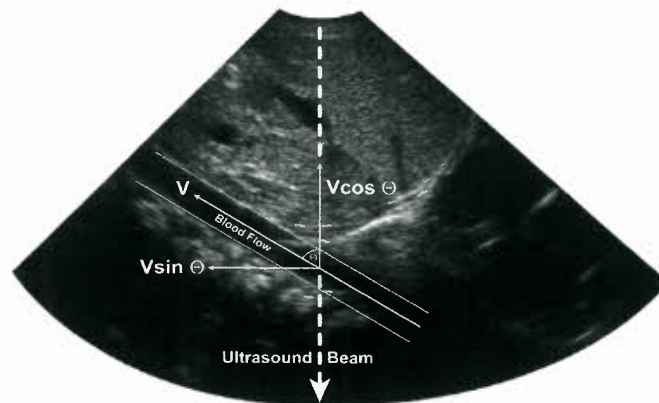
Angle correction for Doppler velocity assessment. The measured Doppler velocity is the velocity vector parallel to the line of insonation (dotted line). The velocity of interest, in this case the velocity of red blood cells coursing through the abdominal aorta or the true velocity, is related to the measured velocity by the cosine of the angle, θ , between the direction of flow and the line of insonation. For $\theta > 20$ degrees, the cosine function becomes significantly less than 1, and will result in significant underestimation of the true velocity, V . The Doppler equation allows calculation of the true velocity even when the angle between the insonation beam and the vector of the true velocity is significant by dividing the frequency shift by $\cos \theta$.
